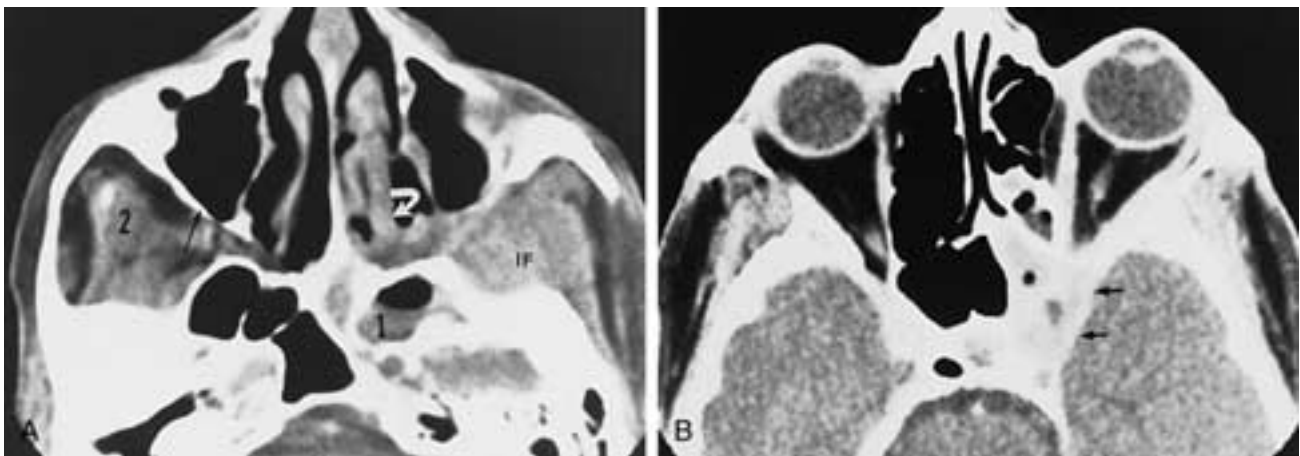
Mucormycosis. A, Axial CT scan shows soft-tissue induration in the left nasal cavity (curved arrow) and left infratemporal fossa (IF). Note the air-fluid level in the left sphenoid sinus (I). Fascial planes in the left infratemporal fossa (IF) region, compared with the right side (2), are obliterated. Note the rarefaction of the posterior wall of the left maxillary sinus compared with the normal right side (black arrow). B, Axial CT scan, same patient as in A, shows involvement of the left cavernous sinus (arrows) with enlargement (engorgement) of the left lateral and medial rectus muscles.
